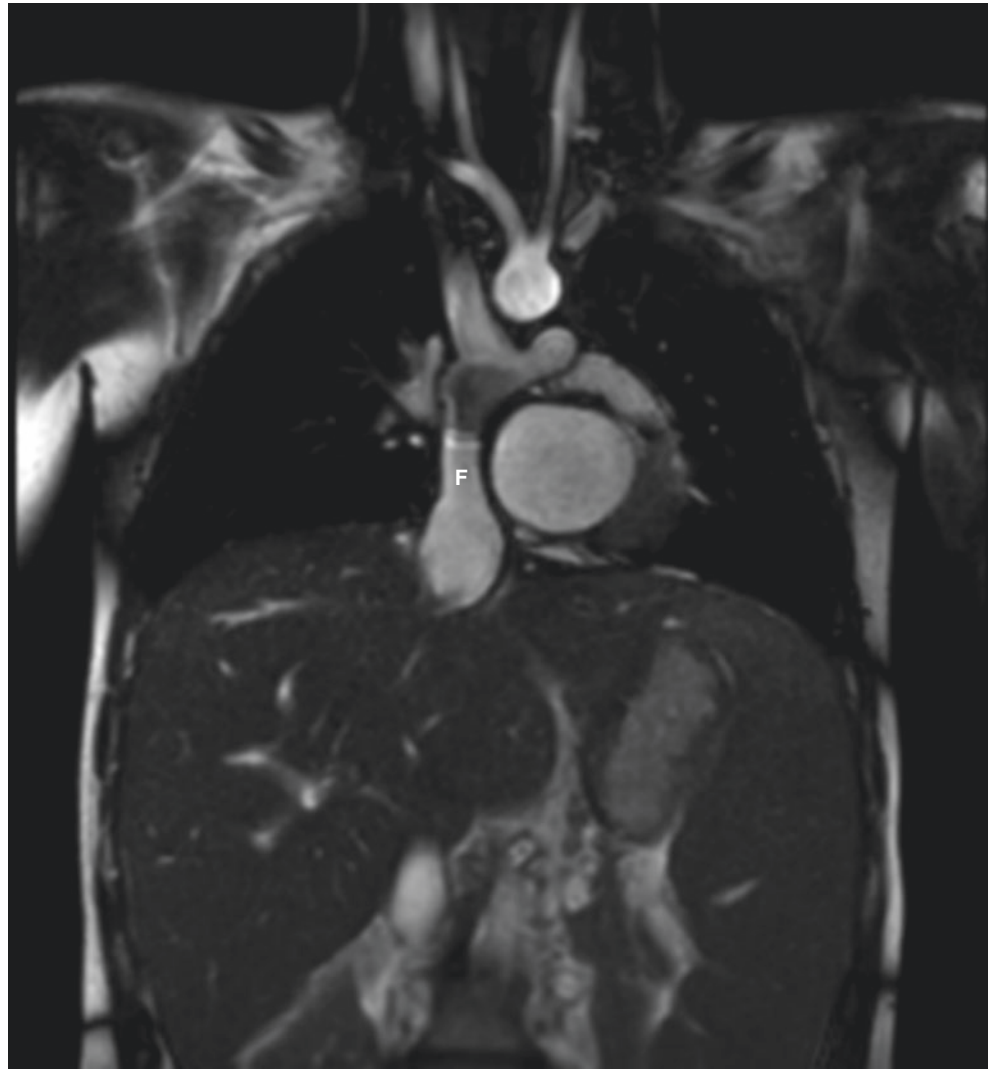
Coronal MRI image showing the entire Fontan pathway. This is an excellent modality for screening for stenosis and thrombus
